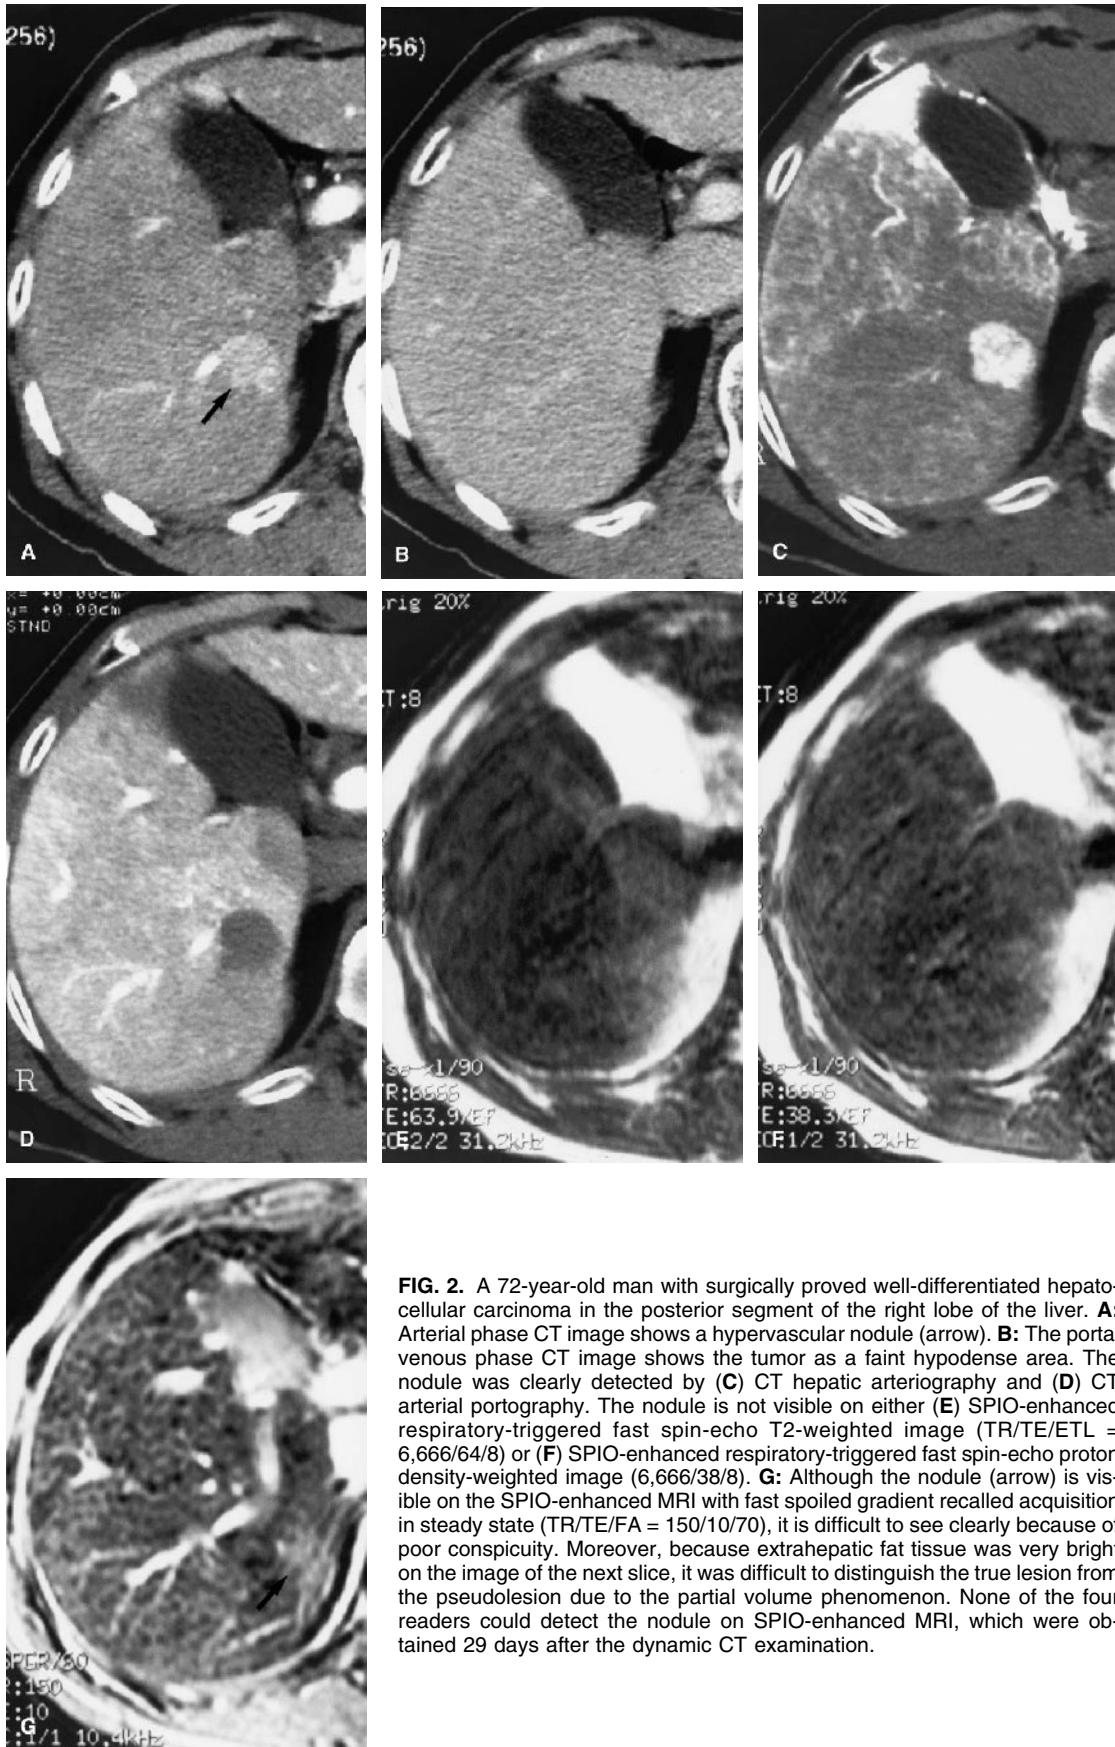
A 72-year-old man with surgically proved well-differentiated hepatocellular carcinoma in the posterior segment of the right lobe of the liver. A: Arterial phase CT image shows a hypervascular nodule (arrow). B: The portal venous phase CT image shows the tumor as a faint hypodense area. The nodule was clearly detected by (C) CT hepatic arteriography and (D) CT arterial portography. The nodule is not visible on either (E) SPIO-enhanced respiratory-triggered fast spin-echo T2-weighted image (TR/TE/ETL = 6,666/64/8) or (F) SPIO-enhanced respiratory-triggered fast spin-echo proton density-weighted image (6,666/38/8). G: Although the nodule (arrow) is visible on the SPIO-enhanced MRI with fast spoiled gradient recalled acquisition in steady state (TR/TE/FA = 150/10/70), it is difficult to see clearly because of poor conspicuity. Moreover, because extrahepatic fat tissue was very bright on the image of the next slice, it was difficult to distinguish the true lesion from the pseudolesion due to the partial volume phenomenon. None of the four readers could detect the nodule on SPIO-enhanced MRI, which were obtained 29 days after the dynamic CT examination.
